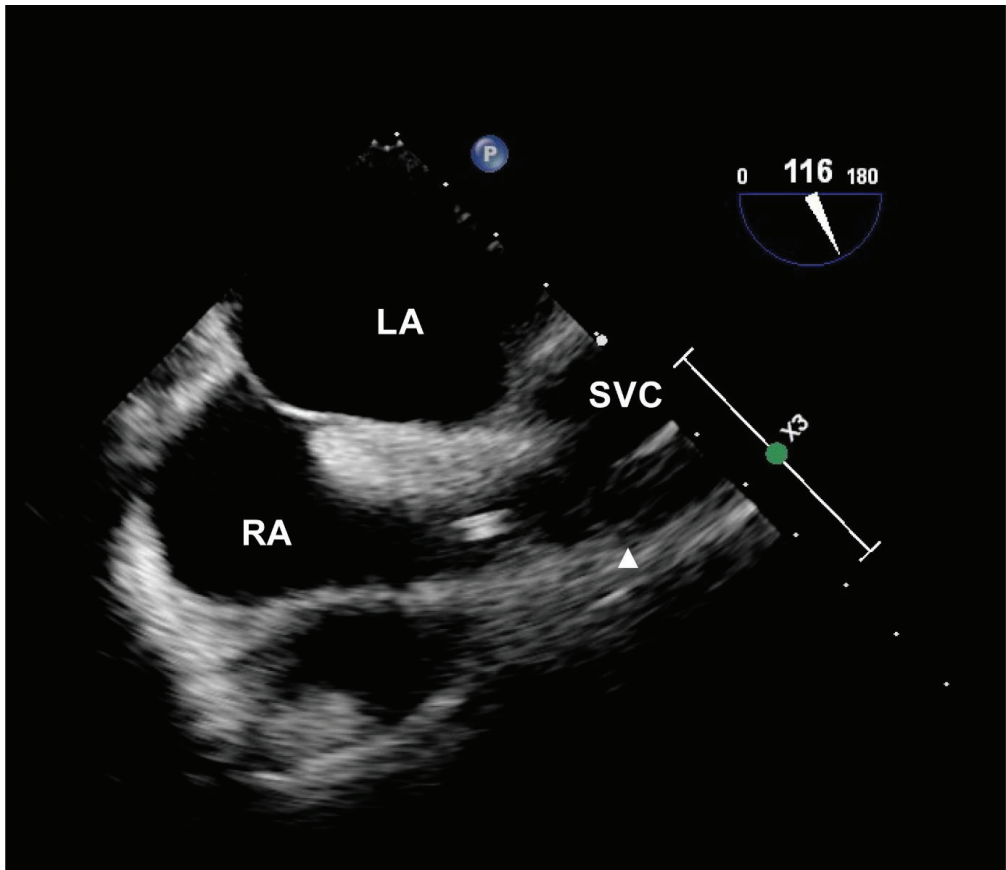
Echocardiographic image of catheter tip positioning. The catheter tip is identified as two parallel echogenic lines from the bicaval view. The solid triangle indicates the level of the upper border of the crista terminalis, defined as the echocardiographic junction of the SVC and the RA. Abbreviations: LA, left atrium; RA, right atrium; SVC, superior vena cava.
